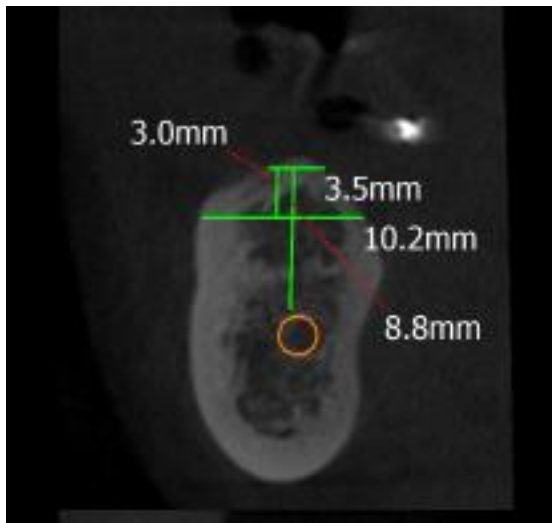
CBCT 3 mm below crest at baseline
